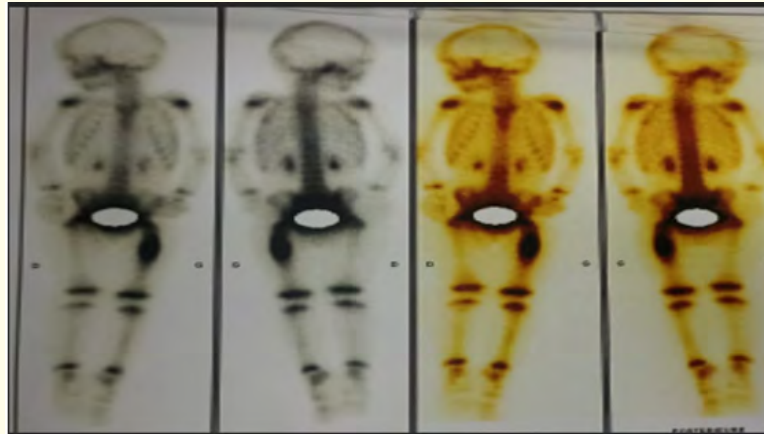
Bone scintigraphy showing intense hyperfixation of the upper and middle parts of the left femoral shaft, without secondary localisation.
